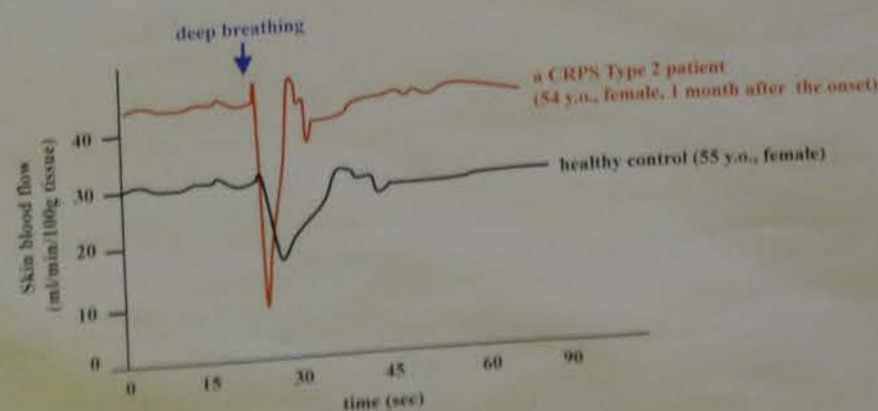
laser-Doppler flowmetry test
